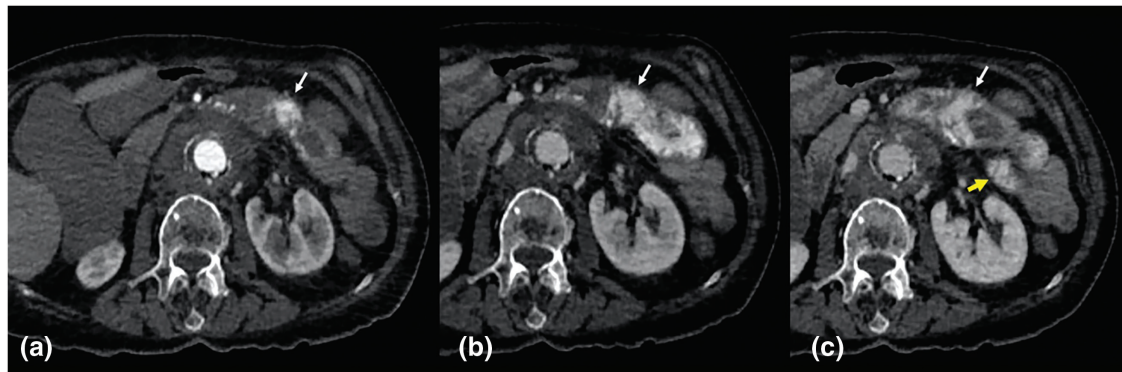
Computed tomography angiography (CTA), axial planes, arterial (a), portal (b) and venous (c) phase: profuse bleeding in the duodenal loops lumen can be seen in (a), (b) and (c) (white arrow). In the venous late phase, the bleeding can be noted also in the jejunal loops lumen (yellow arrow).
